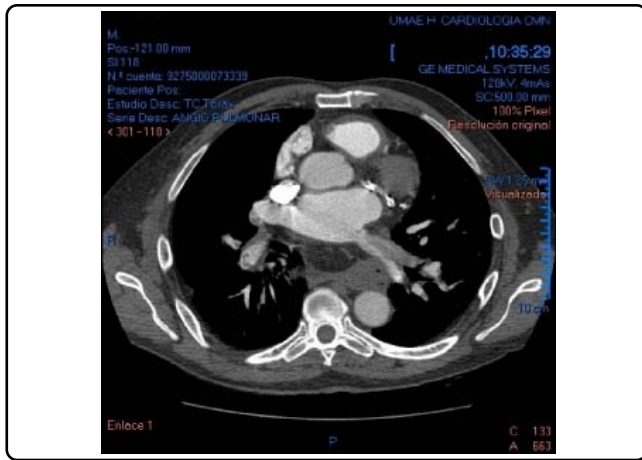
CT axial scan taken after treatment shows the right and left main pulmonary artery division, there is a linear hipodense image that goes into the left artery. This hipodense image is residual blood clot. There are two more hipodense zones on the left side and on the right side. Notice the image of the hernia between the aorta and the pulmonary artery.
